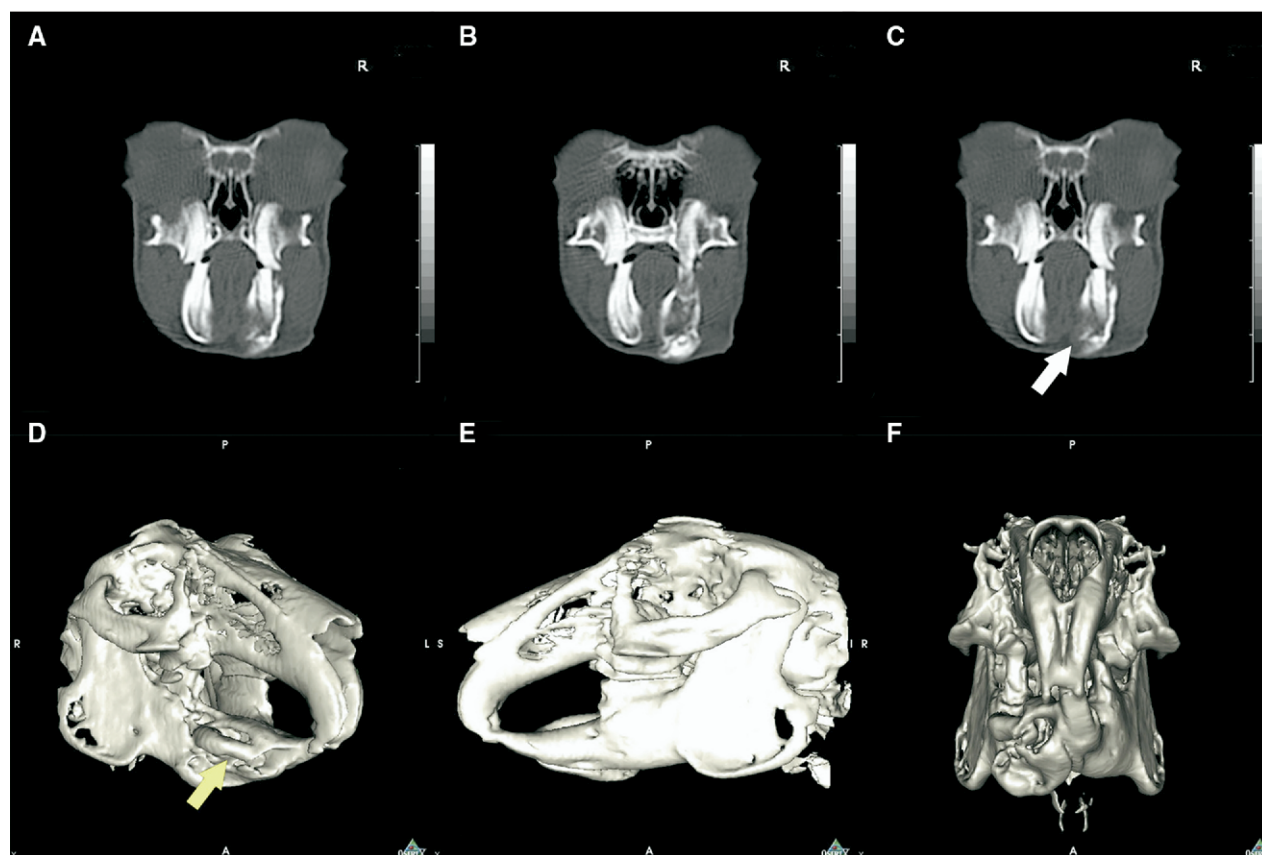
Osteomyelitis of the right mandible after periapical infection of the omolateral incisor tooth; bone window. Scanning parameters: scan speed, 1 sec; mA, 125; kilovolt (peak), 120; slice thickness, 3 mm; reconstruction index, 0.5 mm; WL, 300; WW, 1500; image size (matrix), 512×512 pixels. Comparison between the normal and the diseased body of the mandible is visible (A, B, C). A medial fistula is present at the level of right mandibular check tooth 3 (C, arrow). SSD of the skull in the same patient (D, E, F). The osteomyelitic body of the mandible is visible (D) as well as the apex and fragmented reserve crown of the right mandibular incisor tooth (arrow). The normal left mandible is shown in (E). The comparison between the normal and the diseased mandible is also visible from the rostral view (F). Reprinted from: Capello V, Lennox A: Clinical Radiology of Exotic Companion Mammals. Wiley-Blackwell Publishing (2008), with permission.
